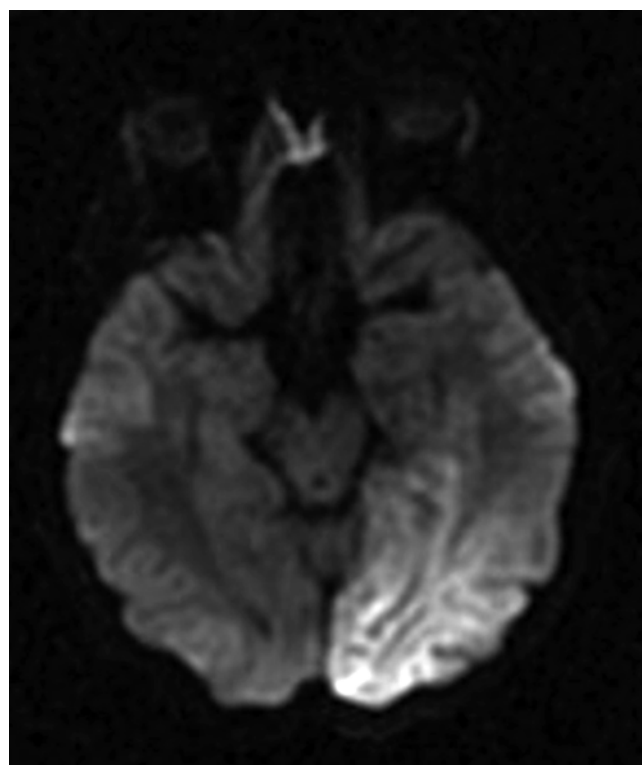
MELAS. MRI, axial view, diffusion weighted imaging, showing acute ischemia in a left parietal and occipital distribution. This stroke-like episode presented with seizure and homonymous hemianopsia; MELAS was confirmed with genetic testing
